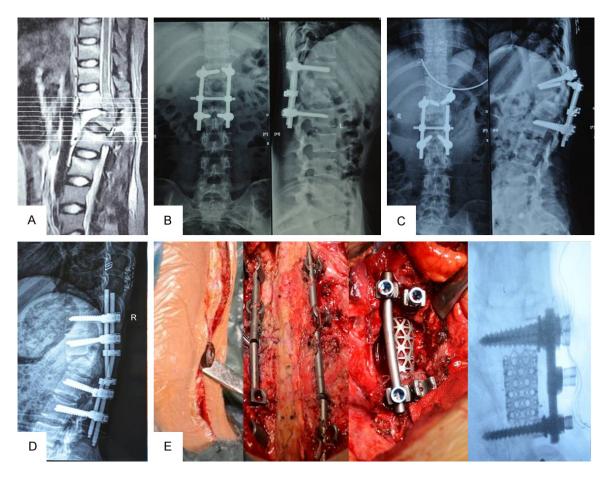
A 27-year-old female with L1 fracture and T12 dislocation underwent a posterior approach surgery in a local hospital. A. MRI showed L1 fracture with T12 dislocation and spinal cord injury; B. posterior short segment fixation was performed in a local hospital, postoperative X-ray showed that L1 had overdistraction; C. 1 year after surgery, X-ray showed screw fracture. D. The connecting rod fracture occurred 1.5 years after the secondary surgery in a local hospital. E. Posterior internal fixation instrument were removed and anterior titanium mesh bone graft fusion was performed in our hospital.
